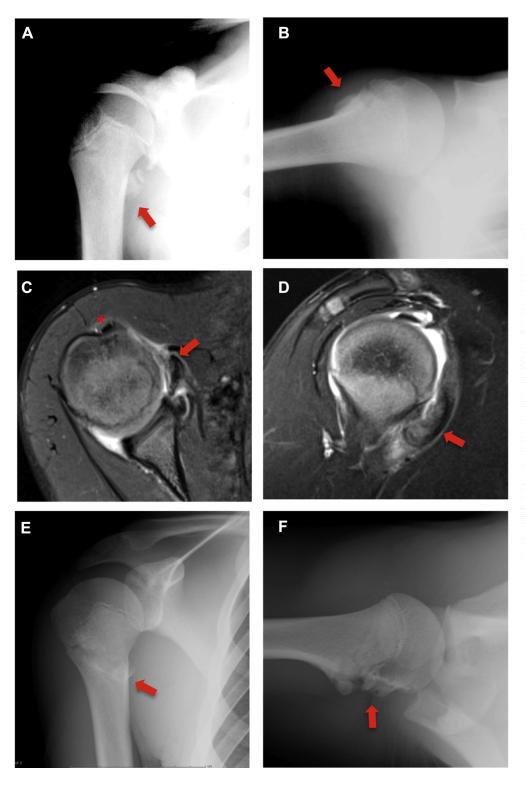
Lesser tuberosity avulsion injury in an 11-year-old lacrosse player. (A) Anteroposterior and (B) axillary radiographs obtained at the time of injury. Injury to the lesser tuberosity is visible on both views (arrows). (C) T2 axial and (D) T2 coronal magnetic resonance images obtained preoperatively show a complete avulsion of the lesser tuberosity with displacement (arrows). The long head of the biceps is present and reduced in the bicipital groove (asterisk). (E) Anteroposterior and (F) axillary radiographs obtained postoperatively show the lesser tuberosity reduction and fixation after open transosseous suture repair (arrows).
